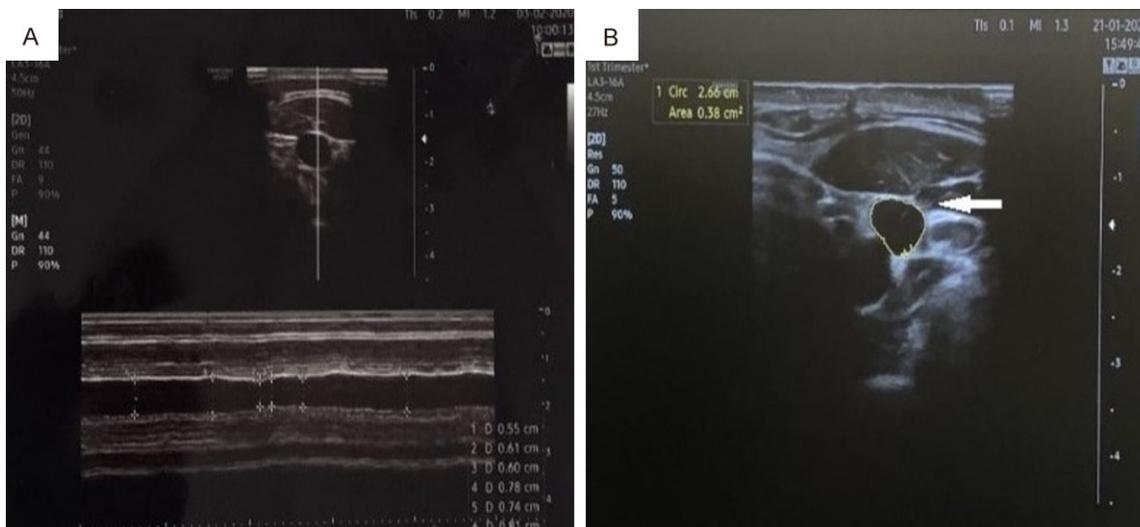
Sonographic M-mode images of (A) maximum and minimum IJV diameter values during the respiratory cycle (at the end of expiration and inspiration, respectively) (B) maximum IJV area (white arrow).
